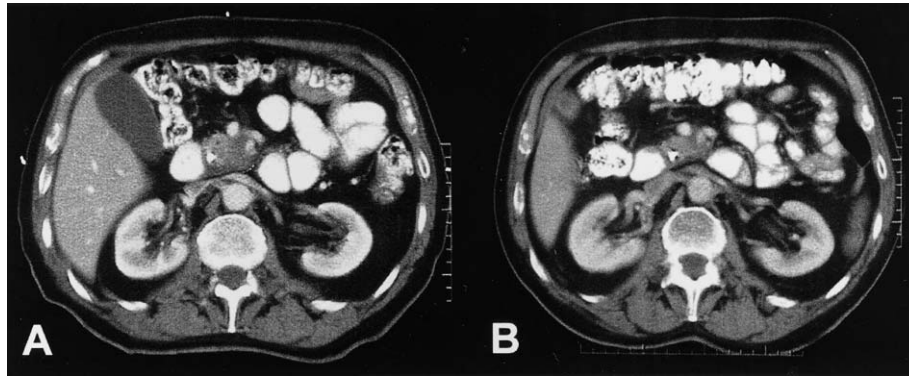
CT scan of a patient initially considered unresectable based on endoscopic ultrasound images and helical CT scans. On retrospective review of the CT scan, the lesion was considered borderline resectable (A). Interval reduction in size was noted after Gem/RT (B), and surgical resection was performed.
